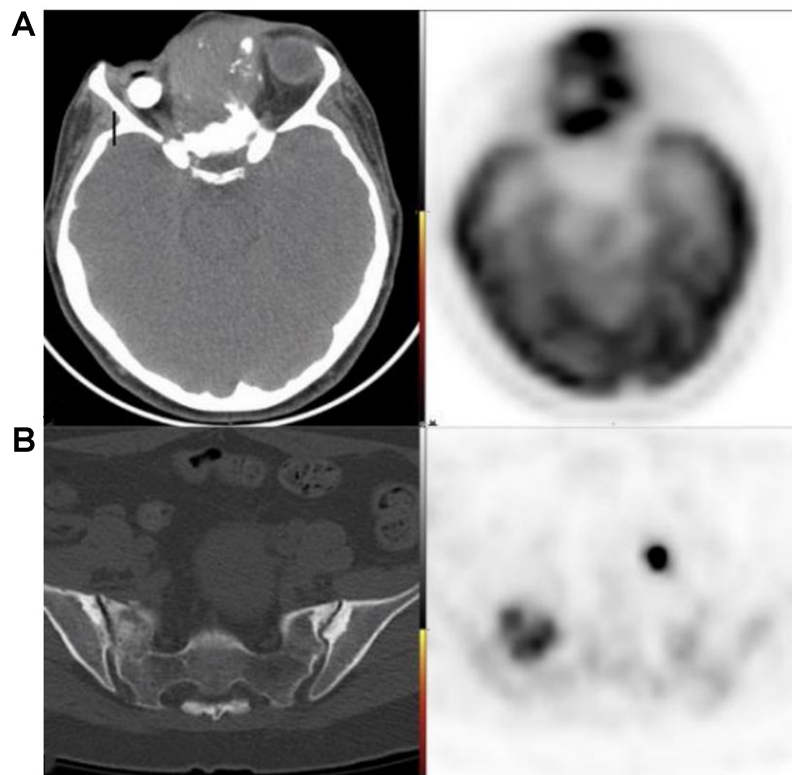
49-year-old female with recurrent AdCC of the ethmoid air cells. (A) FDG PET/CT demonstrating an infiltrative, trans-spatial mass centered in the ethmoid air cells with marked FDG uptake, compatible with local recurrence; (B) FDG PET/CT in the same patient revealing distant osseous metastasis in a sclerotic right sacral ala lesion. AdCC: Adenoid cystic carcinoma; CT: computed tomography.
